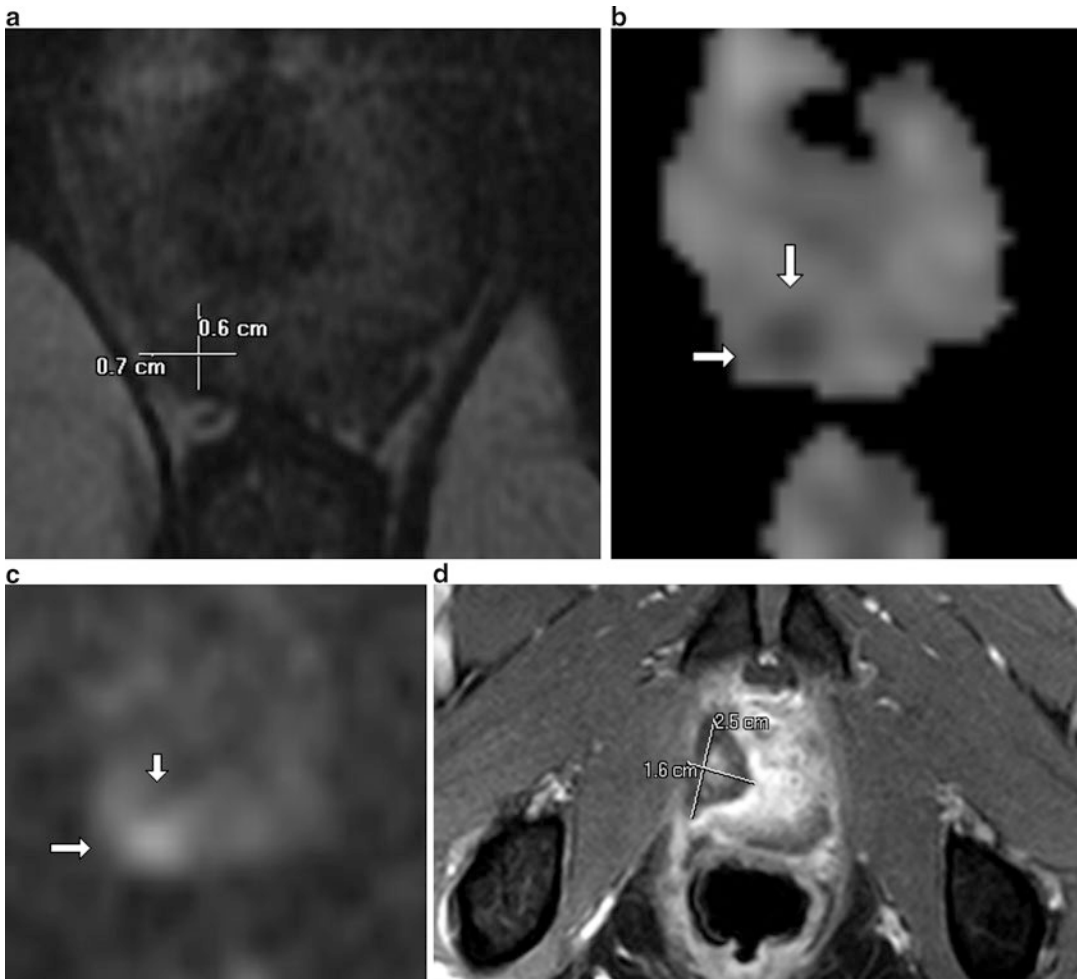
A 60-year-old man with serum prostate-specific antigen (PSA) of 1.1 ng/mL underwent multiparametric magnetic resonance imaging (mpMRI) to assess for prostate cancer. (a) Axial T2WI shows a lesion with low T2 signal intensity in the right posterior peripheral zone (PZ) at the level of the apex (*arrow*). (b) Axial apparent diffusion coefficient (ADC) map shows a corresponding area of restricted diffusion (*arrows*). (c) Perfusion images show early and focal enhancement of the lesion relative to the remainder of the gland (*arrows*). PI-RADS score is 4. The diagnosis was confirmed with MRI-guided in-bore targeted biopsy, which showed Gleason score 4 + 3 = 7 disease. (d) Axial T2WI obtained during focal laser ablation (FLA) of the lesion shows posttreatment coagulation necrosis of the lesion and a margin of surrounding tissue. (e) Sagittal T2WI obtained during FLA of the lesion shows posttreatment coagulation necrosis (*arrow*). PSA level was 1.4 ng/mL 2 months after FLA, so
